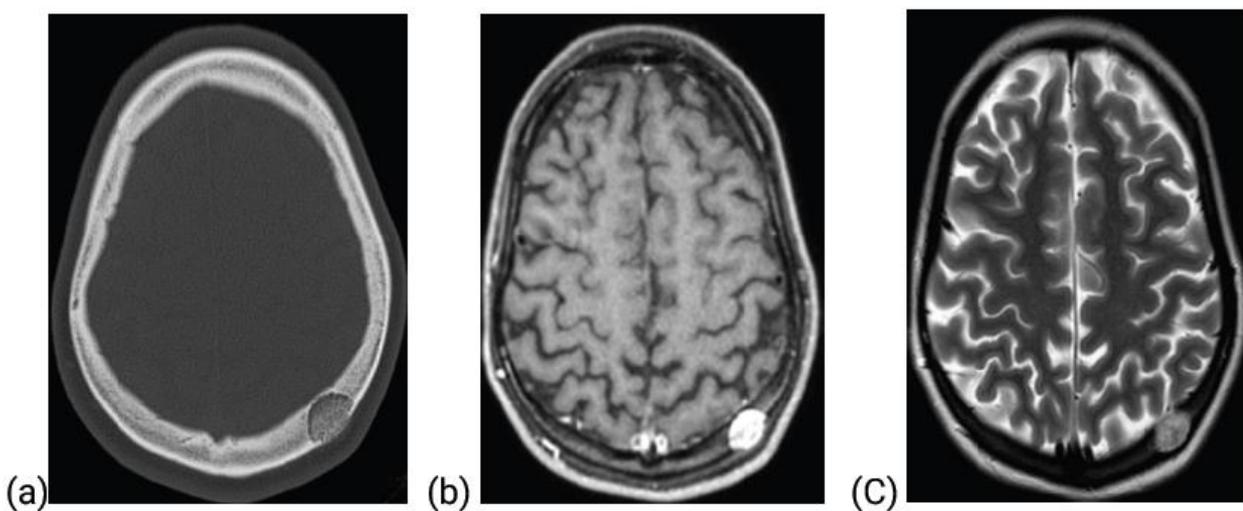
Hemangioma. (a) CT-bone window axial image shows left parietal rounded, diploic, expansile, lytic lesions with sunburst appearance and intact inner table. (b) post contrast T1WI-MRI shows enhanced lesion with intact inner table and eroded outer table with minimal subgaleal soft tissue. (c) T2WI-MRI image shows hyperintense left parietal calvarial lesion.
